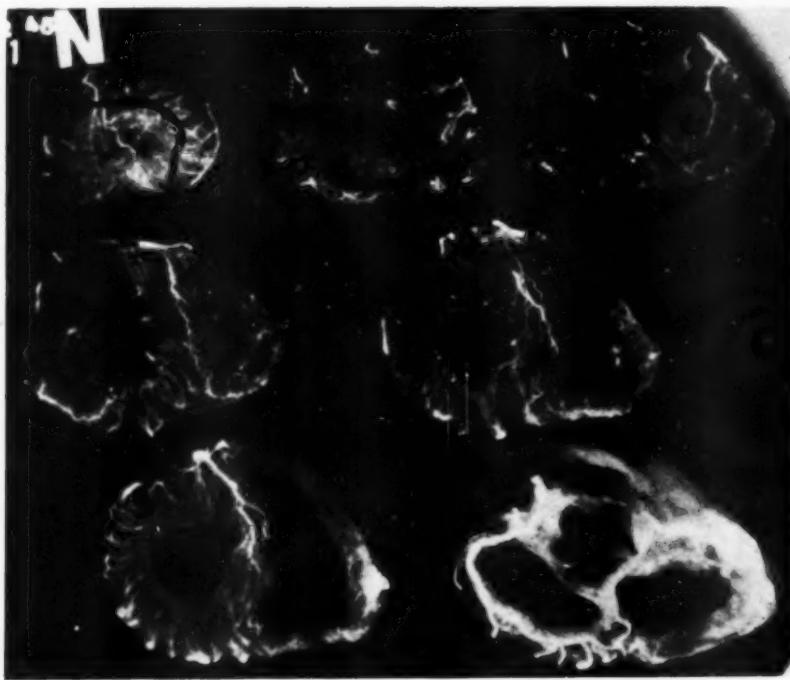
Roentgenogram of the injected heart in Case 64.
